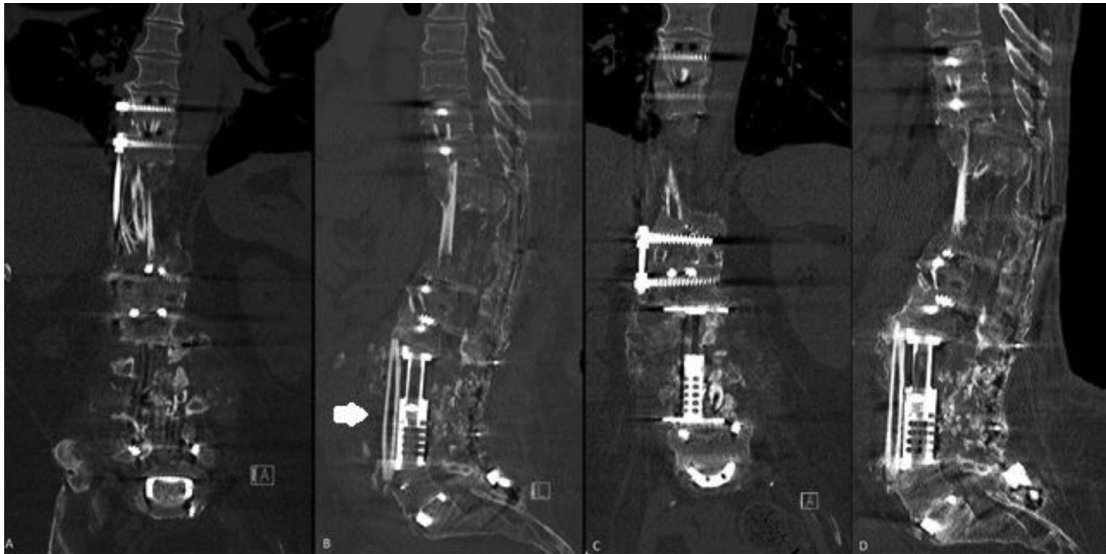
Postoperative CT (A, B) scans after the third operation, with a new cage and a fibula graft anterior to the L2-L5 (white arrow). One year after the last operation, the CT scans (C, D) do not show any visible changes.
